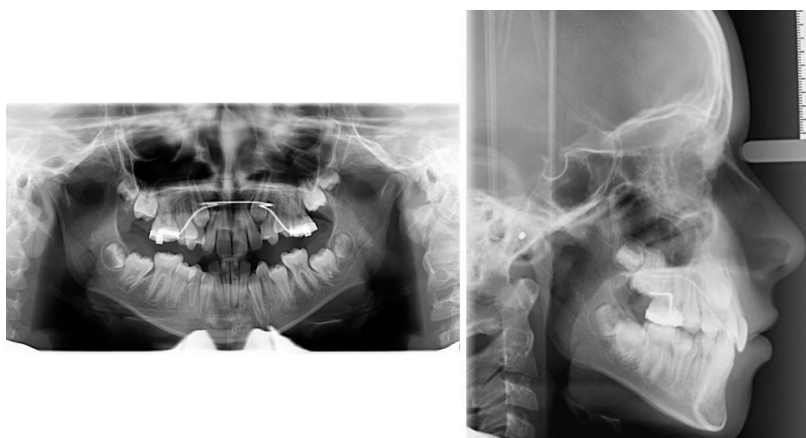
Orthopantomography and Cephalometry before the orthodontic treatment*
